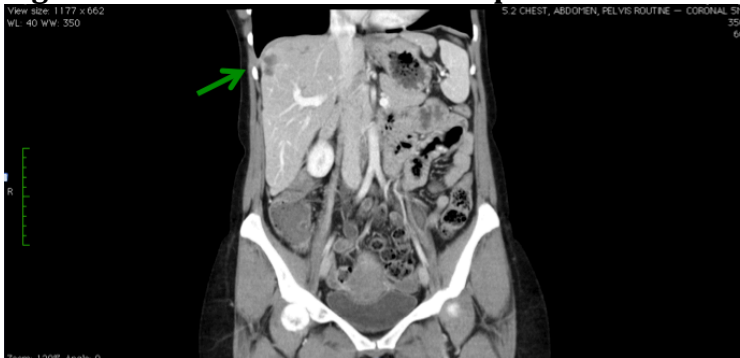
CT scan of abdomen & pelvis - December 2013
